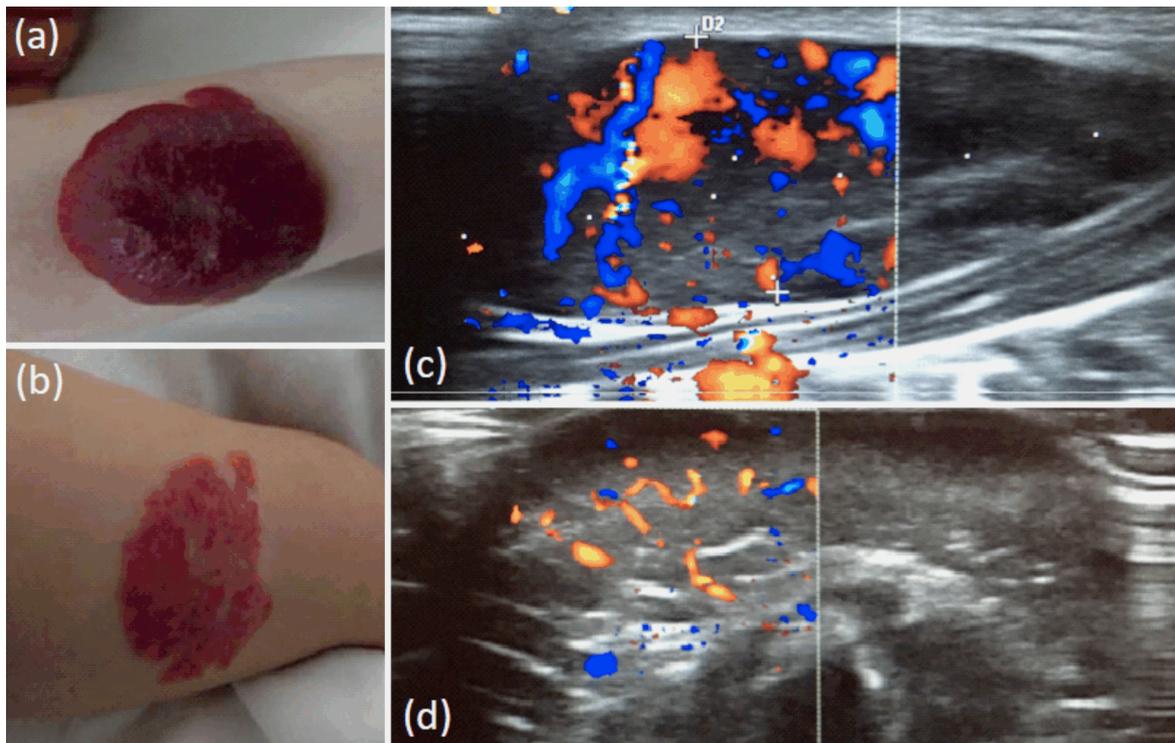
Clinical picture of infantile hemangioma in a 6-week-old girl who presented with a growing strawberry red lesion in the upper limb that was not present at birth (a). The corresponding color Doppler ultrasound examination shows high vascular density characteristic for hemangioma (c). After nine months of treatment with Propranolol, involution of the hemangioma can be observed (b). A decrease in the vascular density can be observed as the result of medical therapy (d).
